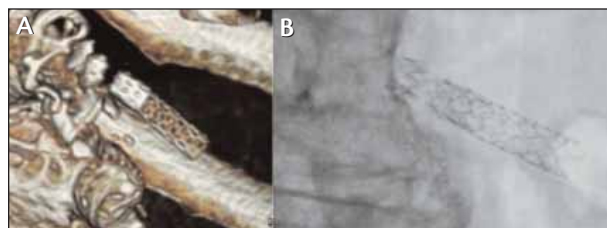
Three-dimensional CT noncontrast showing a patient who received a second renal stent in which the second (more proximal) stent now has a near-complete fracture (A). The patient became more hypertensive, and a follow-up angiogram showed hyperplasia and the fracture was evident on fluoroscopy (B). The patient later underwent an additional stent placement and has done well.
